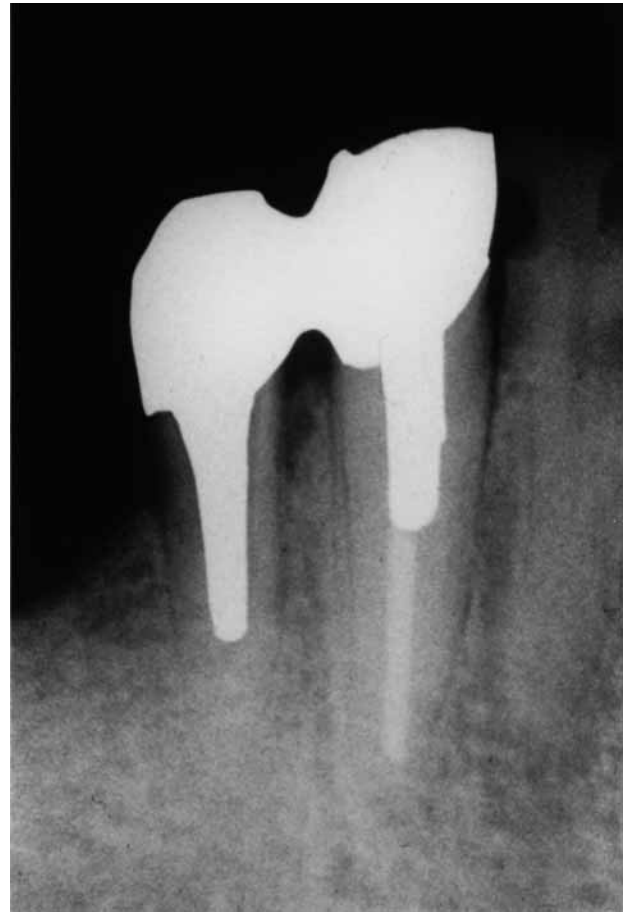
Five years later. Radiograph shows no bone loss. The probing depth was 3 mm.
